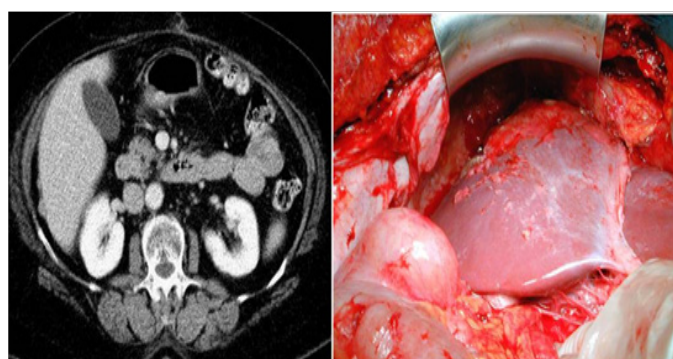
Implants of liver fibrous capsule (Glisson's capsule) on CT scan and intraoperative image.
